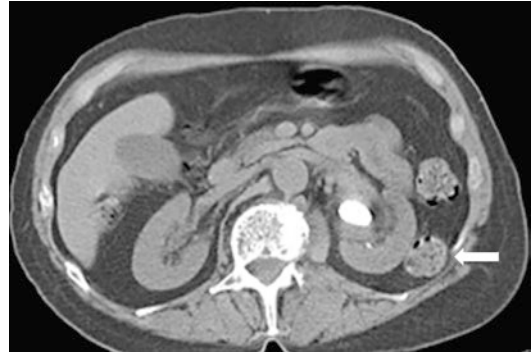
NCCT and perirenal organ mapping. (Non-contrast CT [NCCT] in a female with solitary stone in the left kidney. Examination revealed a retrorenal colon [arrow], which one must be aware, when access is planned)
